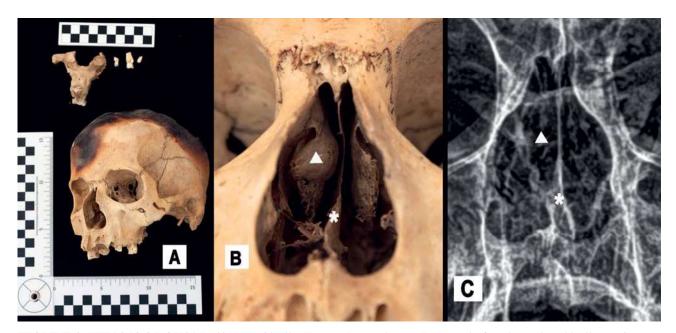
[TT16-10.3-BOX01-Ind01]. A, Skull – Fronto-Lateral view. B, Detail of unilateral and bulbous *Concha Bullosa*. C, antero-posterior X-ray image of the nasal area. White triangle shows the middle turbinates, asterisk the nasal septum.
